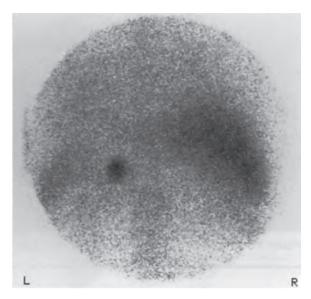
Selenocholesterol scan of a patient with Cushing syndrome due to an adenoma in the left adrenal gland. This technique has now been abandoned owing to unreliability, lack of isotopes and increased accuracy of CT/MRI.
